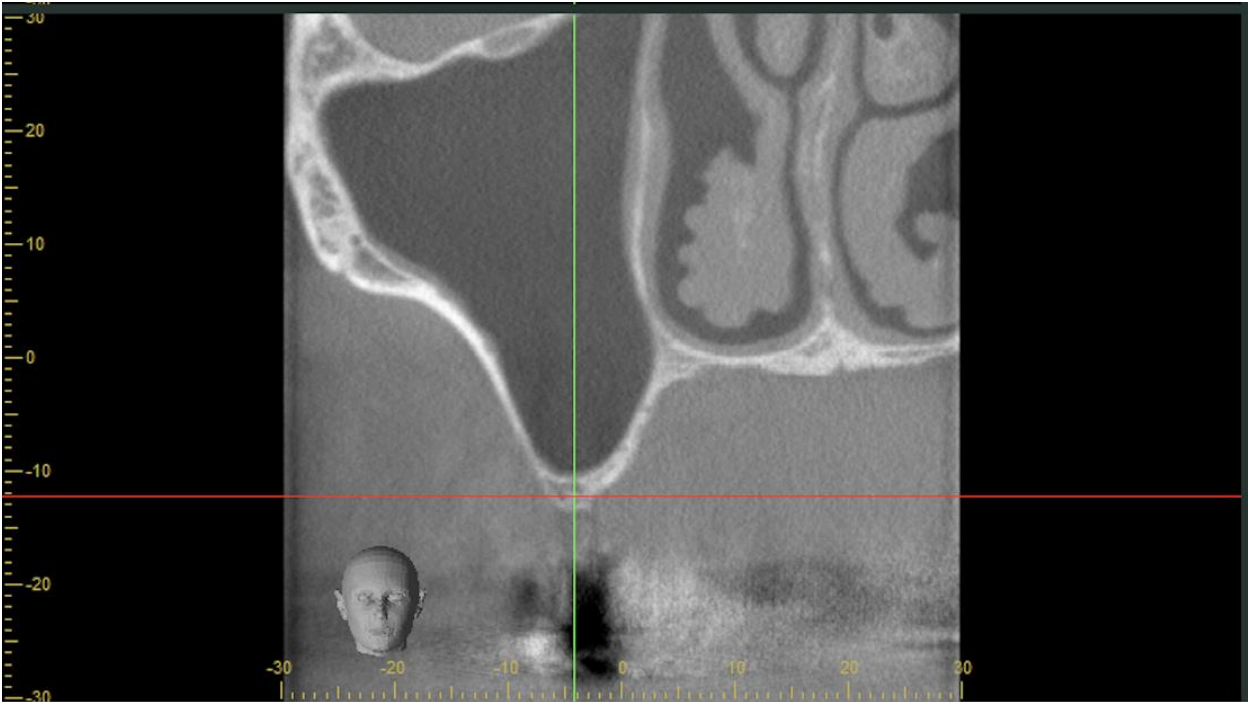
Pre-operative cone-beam computed tomography (CBCT) images
